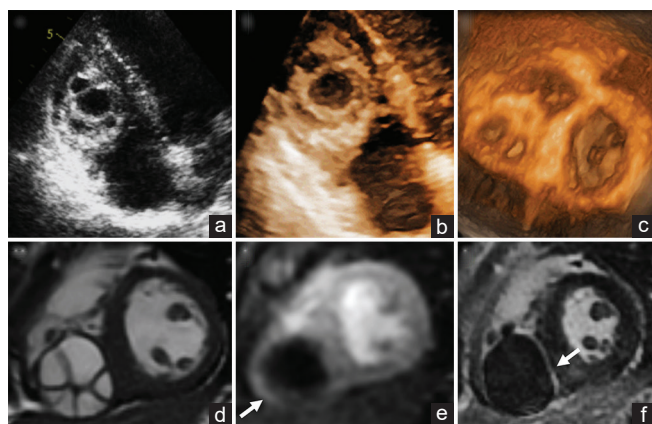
Two-dimensional echocardiography shows a single cardiac cystic mass with anechoic content, multilocular and nonmobile, in the context of right ventricle inflow (a). Three-dimensional-transthoracic echocardiography localized the mass within the posterior right ventricle inflow, possibly with intramyocardial location (b and c). View of the cyst by cardiac magnetic resonance cine-images (d), first-pass perfusion (arrow in e) and late gadolinium enhancement (arrow in f)
